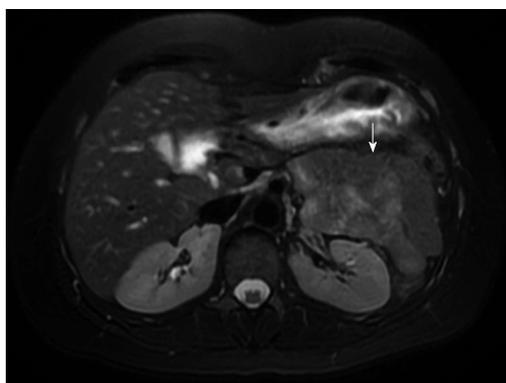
Magnetic resonance imaging of solid pseudopapillary neoplasm (arrow).
